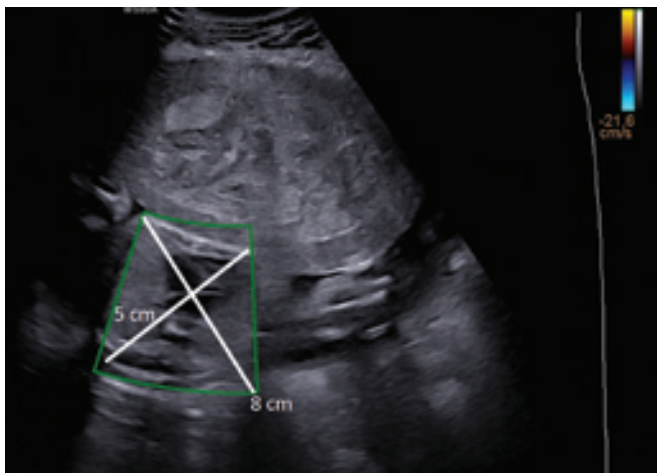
Transabdominal ultrasound performed with a Hera WS80A apparatus (Samsung Corp., Seoul, South Korea): the green ROI (region of interest) shows a retroplacental hematoma measuring 8 × 5 cm.
